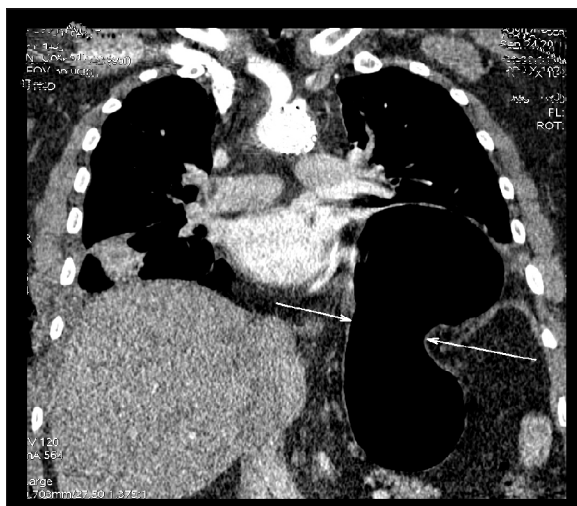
(A, B) A 40-year-old female who had been involved as a passenger in a motor vehicle accident. CT images show a dangling diaphragm sign and herniation of the stomach. Right-sided pneumothorax and fractured ribs and pelvis were also demonstrated (not shown). Left hemidiaphragmatic rupture was confirmed during surgery; the tear was about 12–15 cm long. Stomach and small intestine loops were herniated into the thorax.
